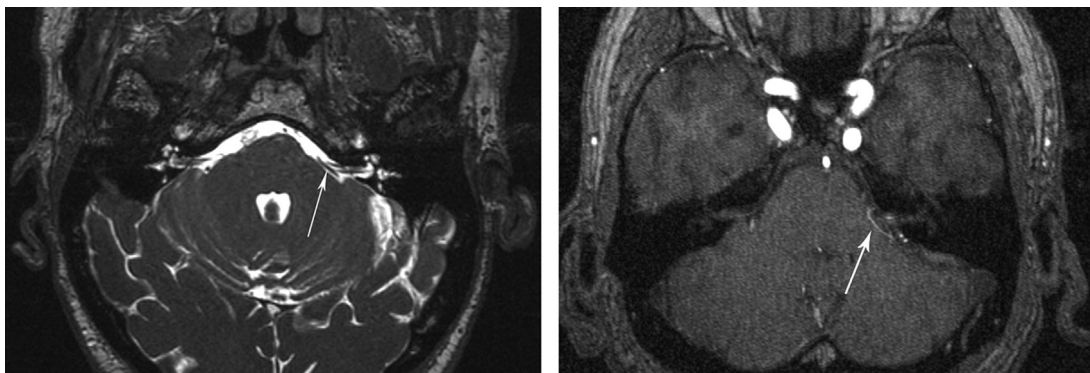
Case 1. Preoperative MRI T2-weighted CISS sequences (left) and 3D-TOF sequences (right) demonstrating a vascular loop (arrow) crossing the left CN VIII in its cisternal segment.
